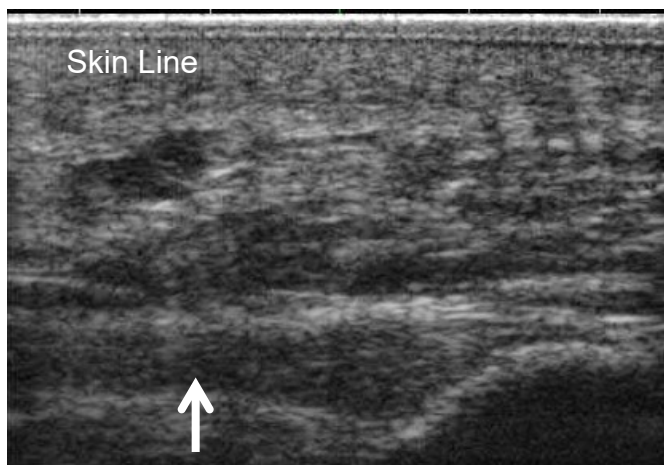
representative long and short axis ultrasound images
